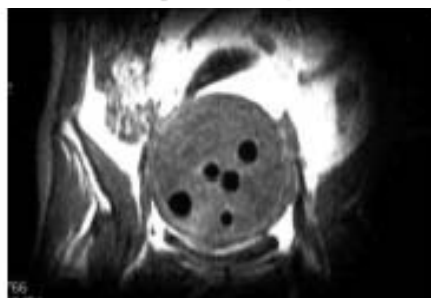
This is an AP projection of the uterine fibroid with five cryoprobes that have been activated for ~2 minutes. Each MRI probe is easily seen.
